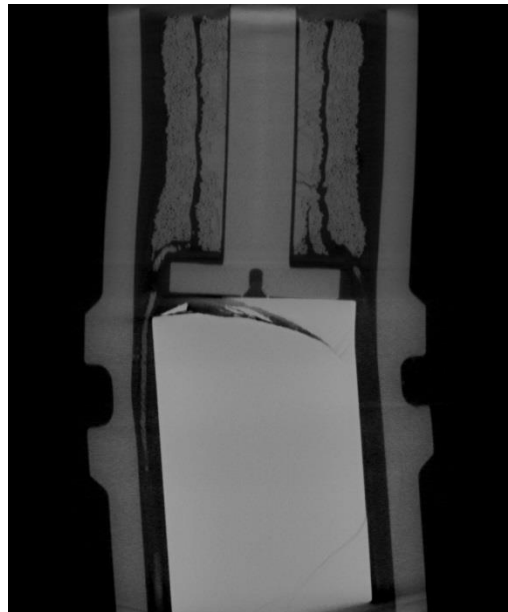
3D X-ray view of ENG 2 torque sensor left S/N CH1468
